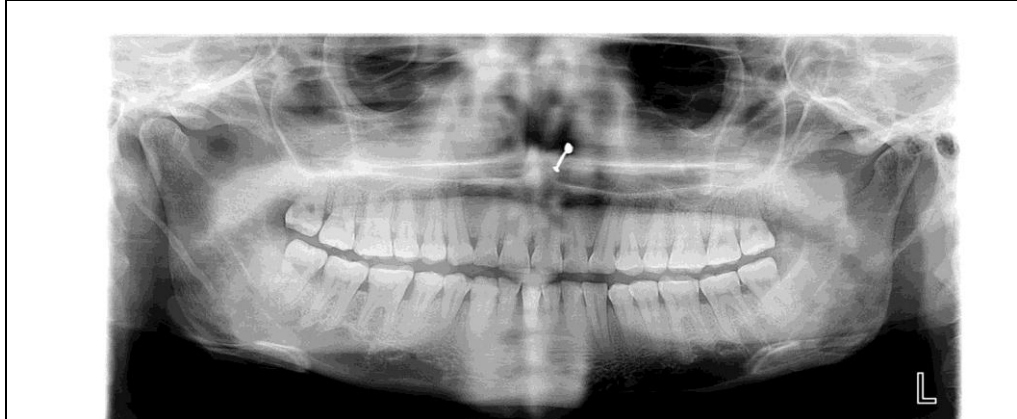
Orthopantomogram shows no abnormality.
